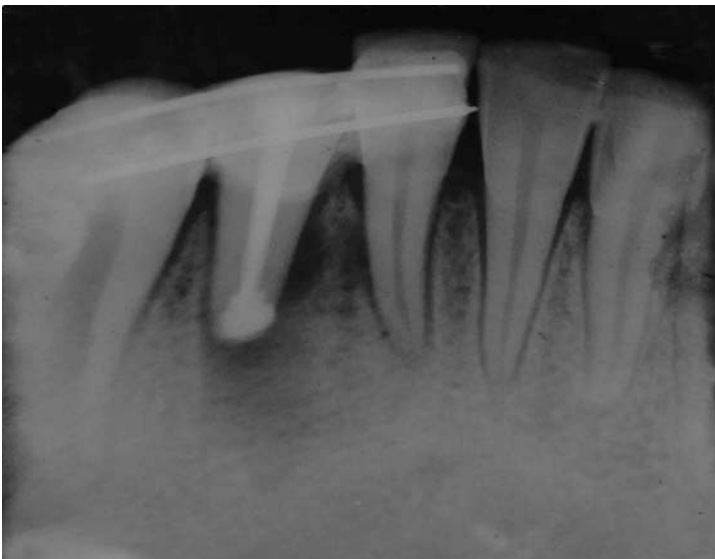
Mandibular left lateral incisor immediately after intentional reimplantation and semi rigid splinting (Intraoral periapical radiograph).
